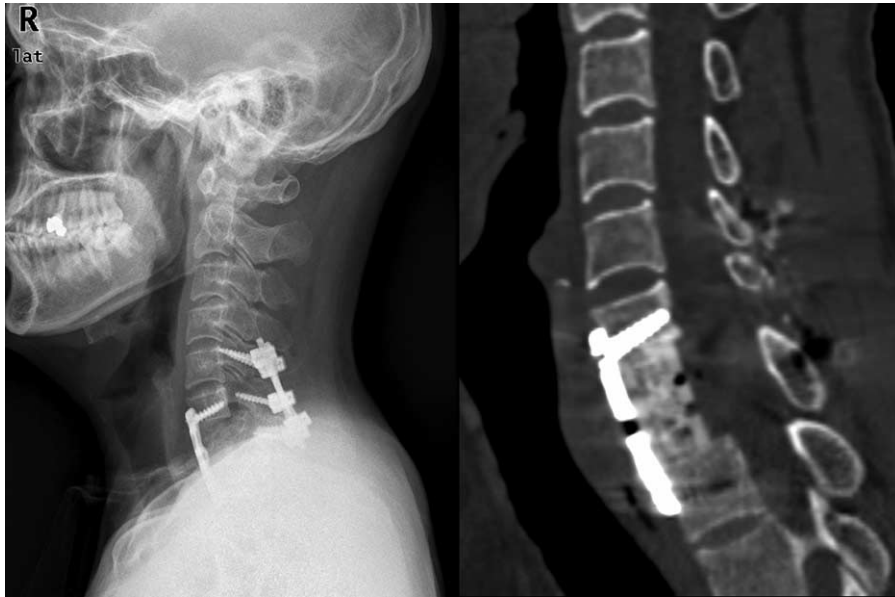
The 3 months postoperative X-ray and computed tomography (CT) scan showed the good position of the implant and bony fusion.
